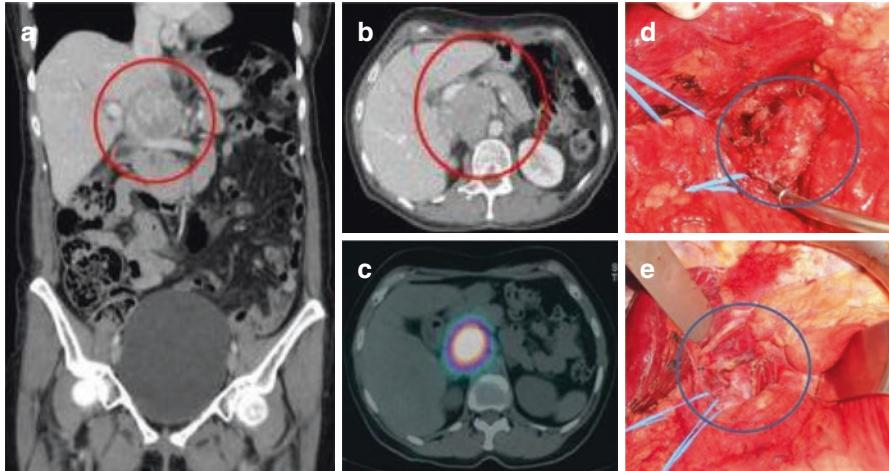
A 74-year-old female patient with difficult to control systemic arterial hypertension. The investigation led to the finding of retroperitoneal mass and elevation of serum catecholamines. The patient was treated with alpha-adrenergic block and prepared for surgery. (a, b) CT shows a solid vascularized lesion with signs of compression of the portal vein and inferior vena cava, insinuating itself posteriorly to the hepatic hilum. (c) MIBG scintigraphy showing the tumor in the highlight area. (d) Intraoperative appearance of the tumor and vascular control of the portal vein and inferior vena cava. (e) View of the operative field with exposure of the inferior vena cava and segment I of the liver after complete resection. Definitive diagnosis of paraganglioma. (Courtesy of Frederico José Teixeira Junior, oncologic surgery)
